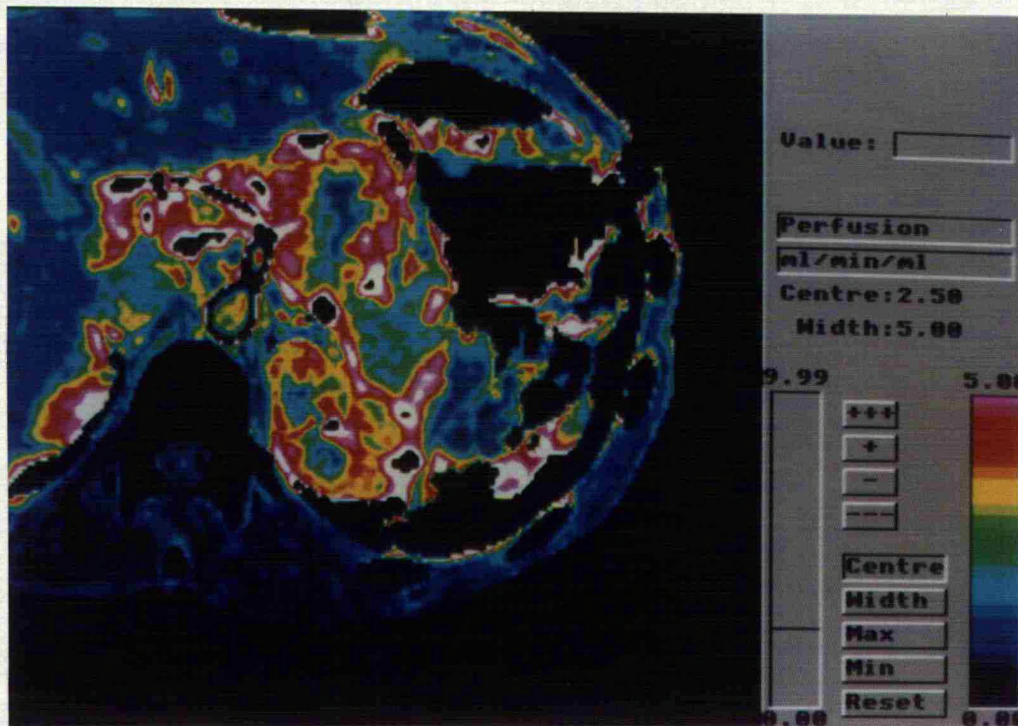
Conventional unenhanced CT (above) and perfusion images (below) of case 2: Islet cell tumour
